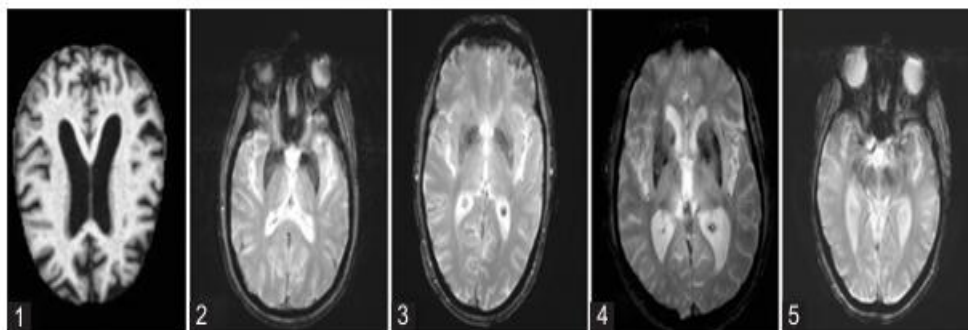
Collections of magnetic resonance imaging pictures that show various phases of Alzheimer's disease (AD). 1. AD, 2. late mild dementia 3. mild cerebral problems, 4. early mild cerebral deficit, and 5. intellectually normal.
